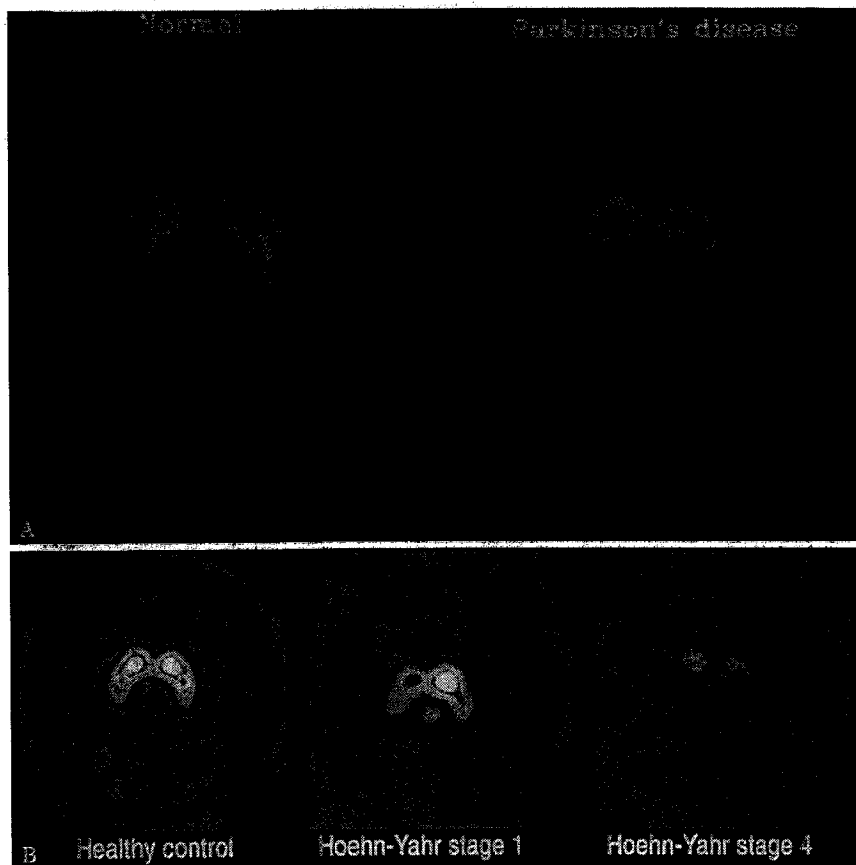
(A) FD-PET scans demonstrate diminished uptake in the brain, particularly in the posterior putamen in PD patients compared with normal controls. (B) β -CIT-SPECT scans demonstrate diminished uptake in the posterior putamen which decreases with the severity of PD. (Courtesy of K.L. Marek.)
